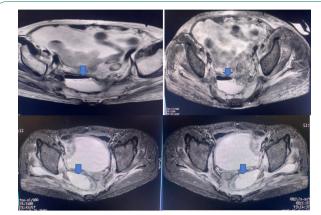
MRI pelvis showing collection in presacral area.
